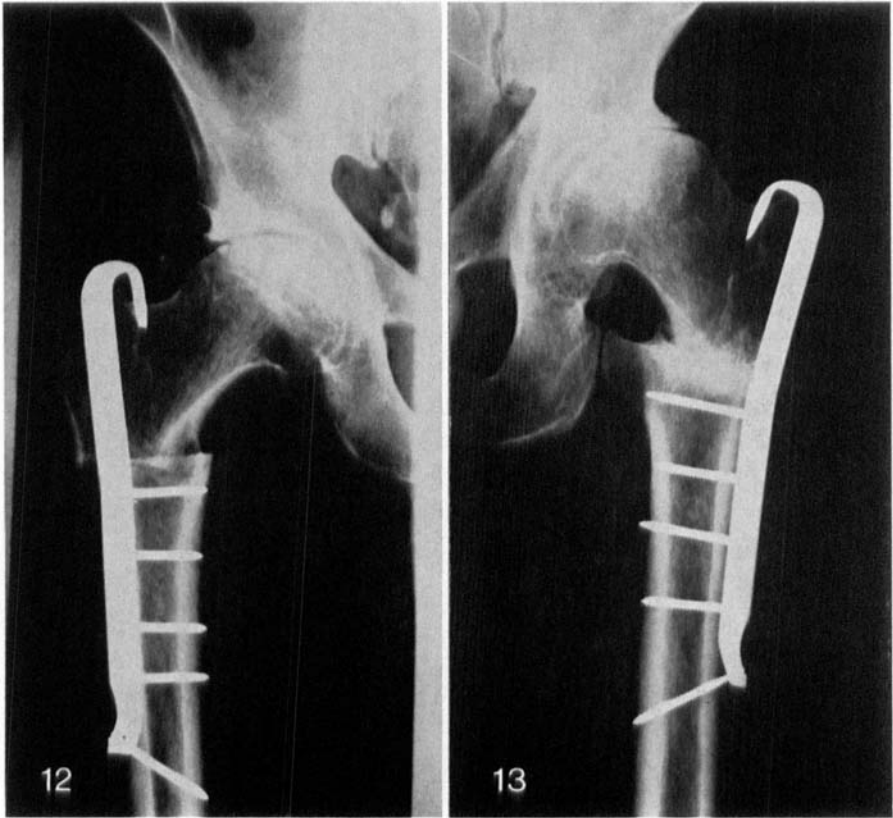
shows an X-ray picture of a wedge osteotomy at a varus angulation of 10 degrees immediately after operation. Figure 13 shows a simple osteotomy, healed.
